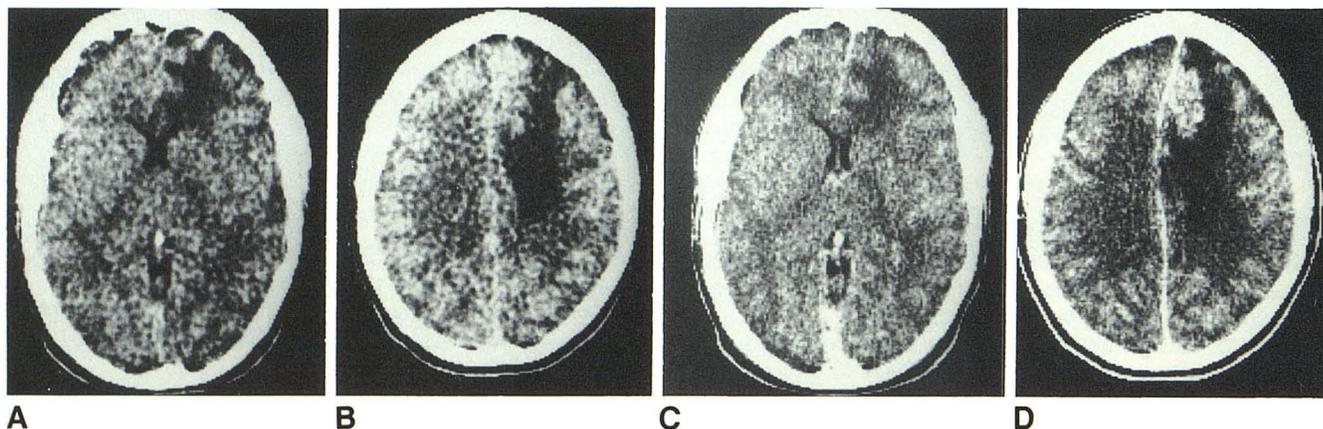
A and B, Unenhanced CT scans. Large area of low density suggesting edema in right frontal lobe. Associated compression of right frontal horn. Sulci not visible. C and D, Contrast-enhanced scan. Moderate nodular
